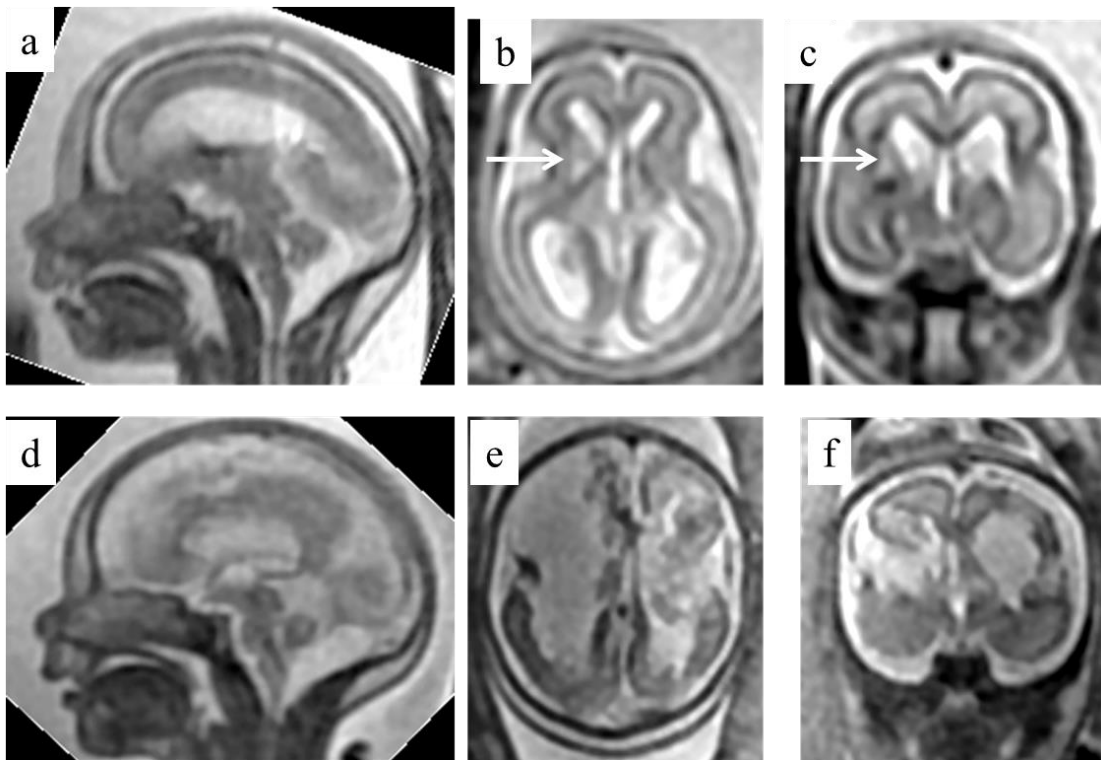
Recurrent, multifocal stroke. Sagittal (2a), axial (2b) and coronal (2c) T2-weighted images of a 21gw fetus investigated for ventriculomegaly diagnosed on ultrasonography. Mild ventriculomegaly was confirmed and there was abnormal signal in the right basal ganglia consistent with infarction (arrowed on 2b and 2c). Repeat imaging at 26gw (2d-2f) showed progressive ventriculomegaly and multiple areas of infarction some associated with haemorrhage. A subsequent diagnosis of a COL4A1-related disorder was made.
